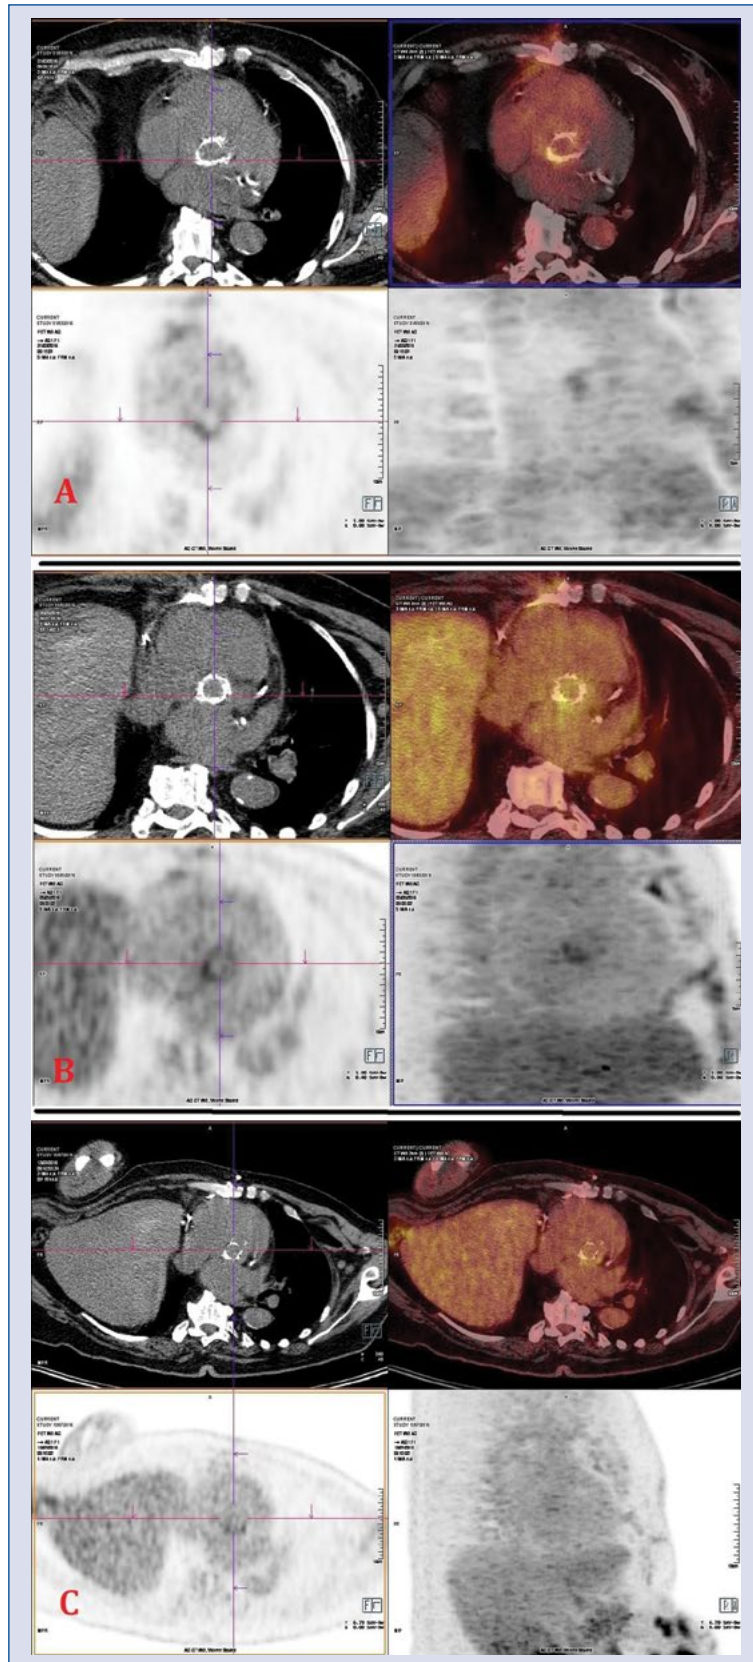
The 18-fluorine-fluorodeoxyglucose positron-emission-tomography/computed tomography (18F-FDG PET/CT) images obtained from the patient showing changes in metabolic activity around the aortic bioprosthesis; A. After initial antimicrobial therapy; B. Before subcutaneous implantable cardioverter-defibrillator implantation; C. During the second hospitalization.
